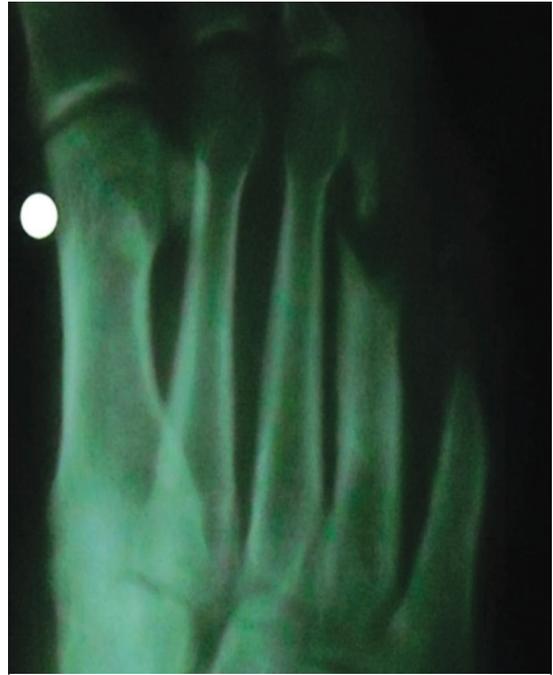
Radiography showed pathological fracture with Osteomyelitic changes seen of the right fourth and fifth metatarsal with narrowing of shafts suggestive of neurotropic disorder.
